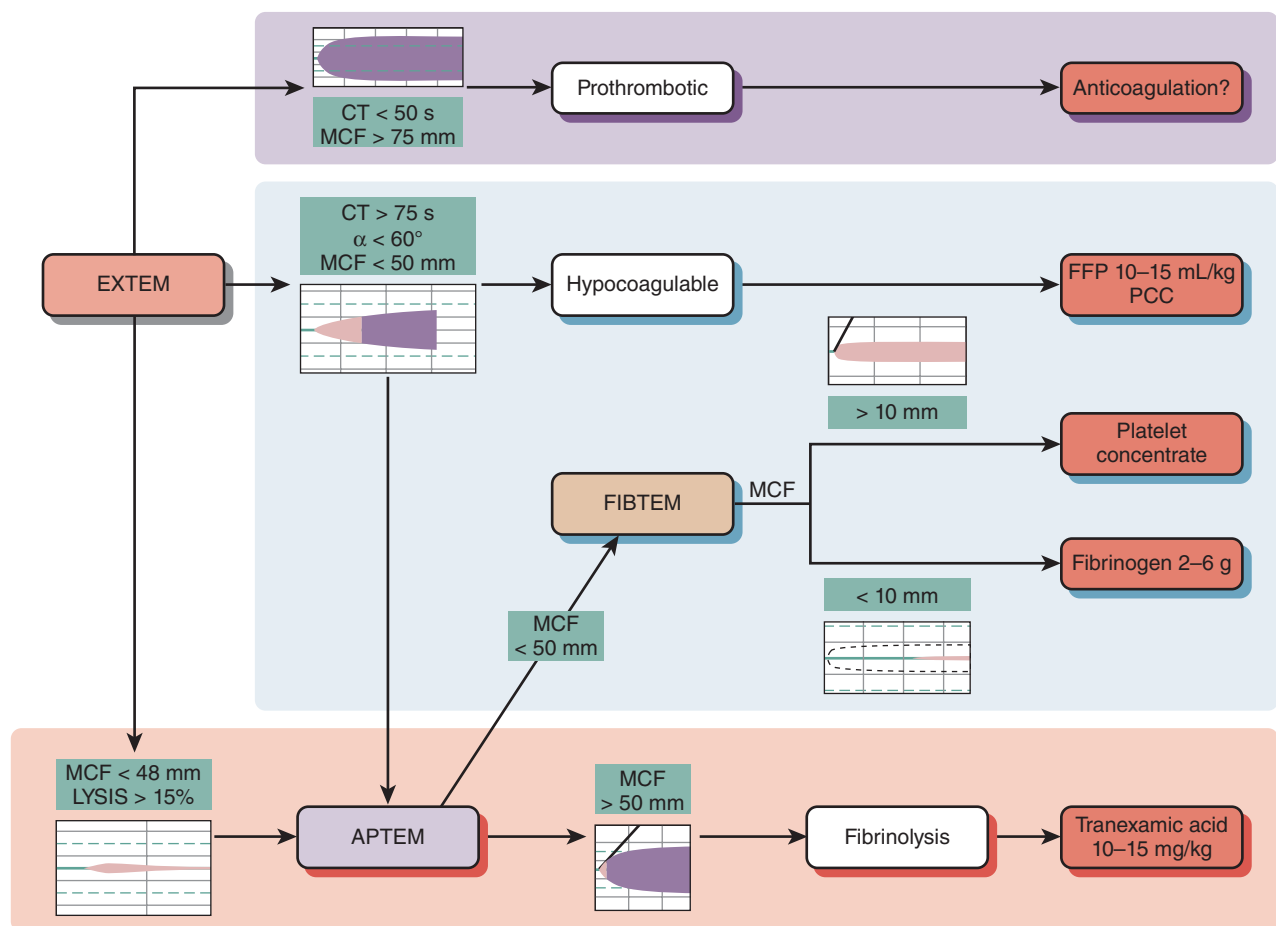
Coagulation management algorithm guided by rotational thrombelastometry (ROTEM, TEM Systems, Durham, NC). α , α Angle; APTEM, tissue factor activation + tranexamic acid/aprotinin; CT, clotting time; EXTEM, extrinsic system; FFP, fresh frozen plasma; FIBTEM, measure of fibrinogen activity; MCF, maximum clot firmness; PCC, prothrombin complex concentrate.
